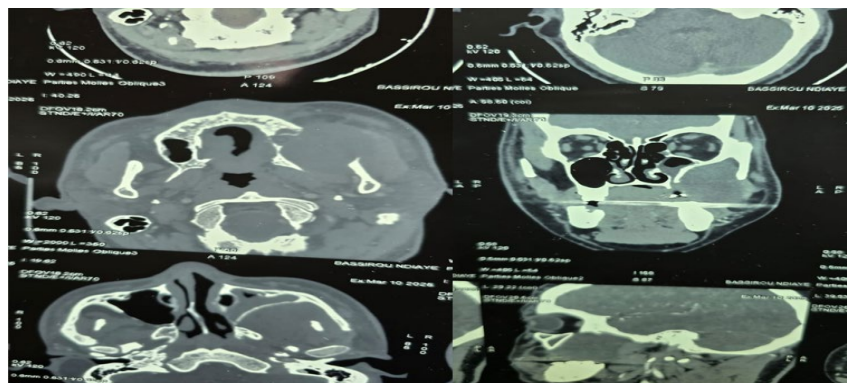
Computed tomography demonstrating a soft tissue mass in the left infraorbital region associated with adjacent bone erosion.
